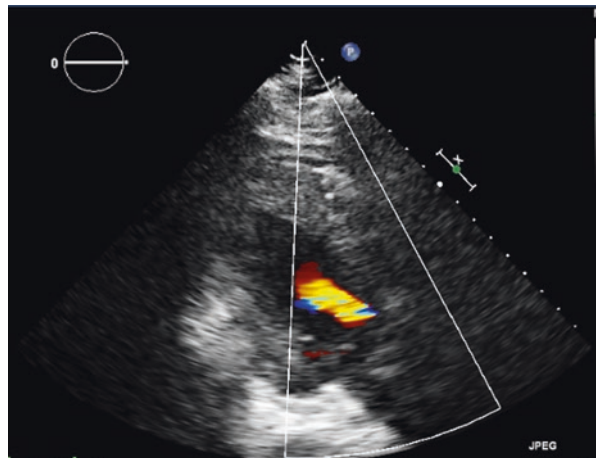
Transesophageal echocardiogram is depicting aortic regurgitation in the same patient with an acute aortic dissection
